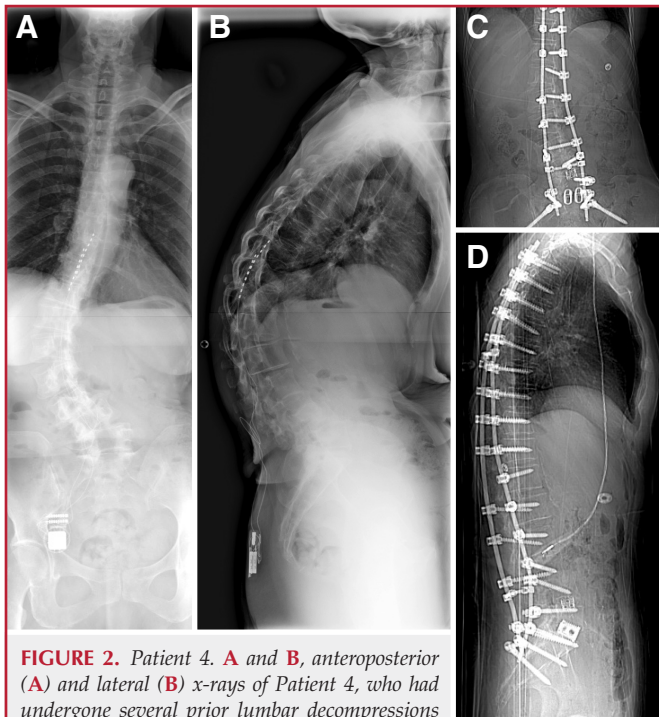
Patient 4. A and B, anteroposterior (A) and lateral (B) x-rays of Patient 4, who had undergone several prior lumbar decompressions and insertion of a dorsal column stimulator for persistent back and leg pain. Her scoliosis progressed after the lumbar decompressions, and the stimulator did not help her back pain. C and D, anteroposterior (C) and lateral (D) x-rays obtained after removal of dorsal column stimulator, further lumbar decompression, and then spinopelvic fixation using iliac bolts (fixed-angle iliac screws)(Liberty; Medtronic Sofamor Danek, Memphis, TN) linked to the lumbosacral rod (Legacy; Medtronic Sofamor Danek) with a fixed offset connector. Note also the anterior lumbar interbody fusion (ALIF) at L4–S1.
